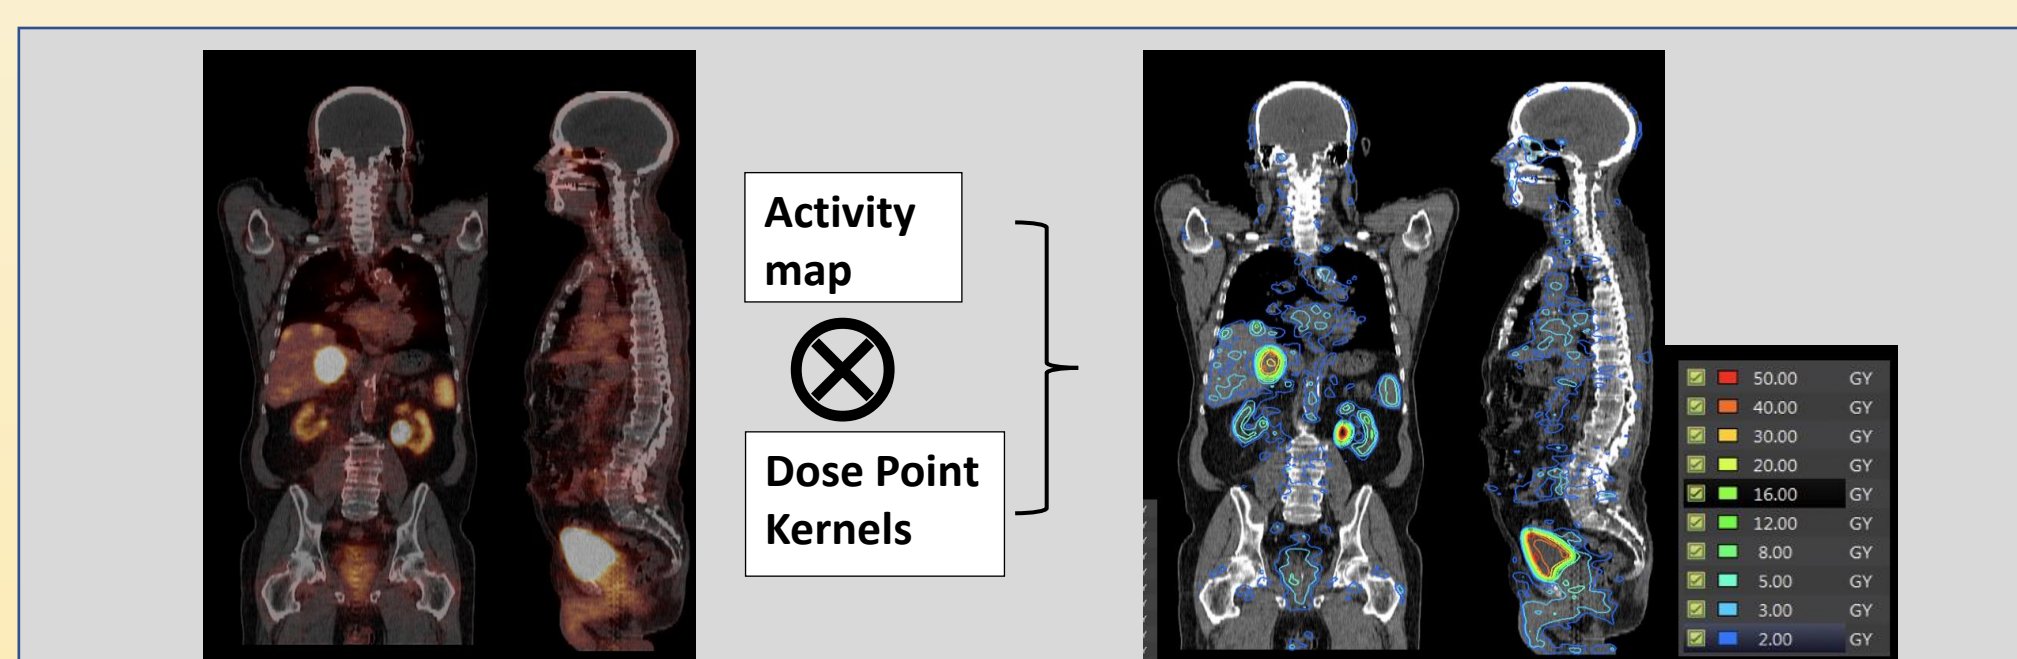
PET/CT scan of patient and dose calculations from convolution with the full-sized kernel (I-131).
